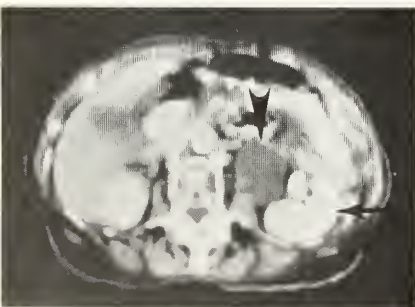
Left hydroureter on CT scan.
